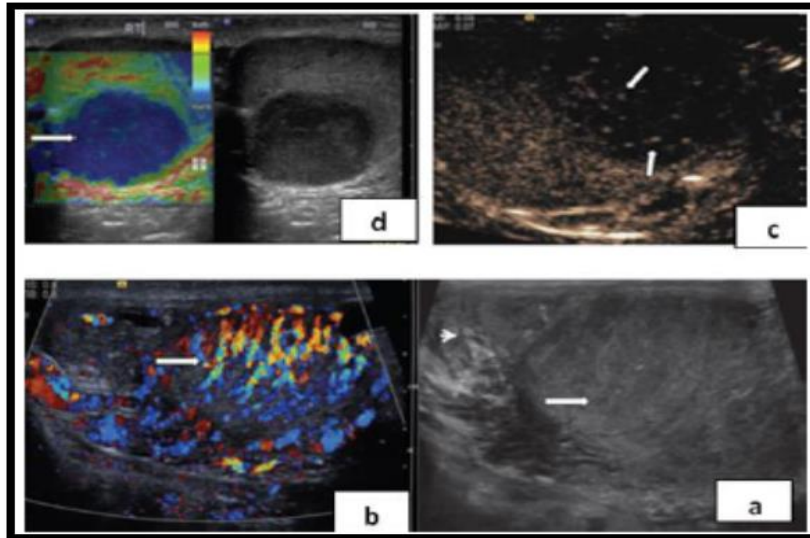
shows the embryonic cell tumor (a) B-Mode ultrasound demonstrates a focal lesion with a slightly heterogeneous reflectivity (arrow). (b)Color Doppler ultrasound demonstrates loss of normal parenchymal vascular pattern, replaced by an abnormal vascularity (the “crisscross”vascular pattern; arrow). Color Doppler flow is demonstrated in the large vessels only. (c) Tissue elastography demonstrates a ‘blue’ lesion, therefore clearly a “hard” lesion (arrow) (d) in contrast-enhanced ultrasound, particulate movement of contrast (arrows) are seen throughout the lesion in a haphazard pattern, confirming the vascularity is present within all components of the lesion(Ercan et al, 2007).
